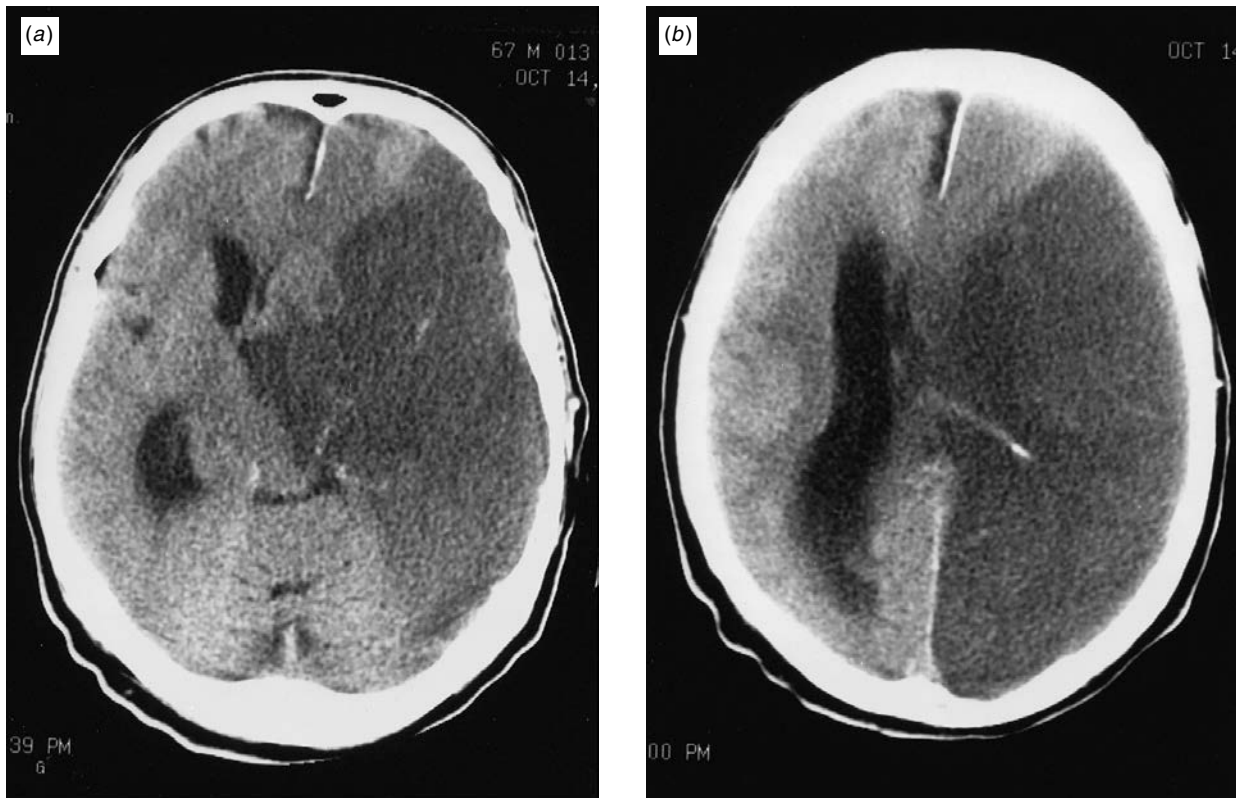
(a), (b). Head CT scan of an 80-year-old man with right MCA infarction and uncal herniation. He had unilateral pupillary dilatation. The herniation caused the infarct of the midbrain region (a) and the right occipital lobe. Both areas are perfused by the right PCA. The region supplied by the ACA is spared.
